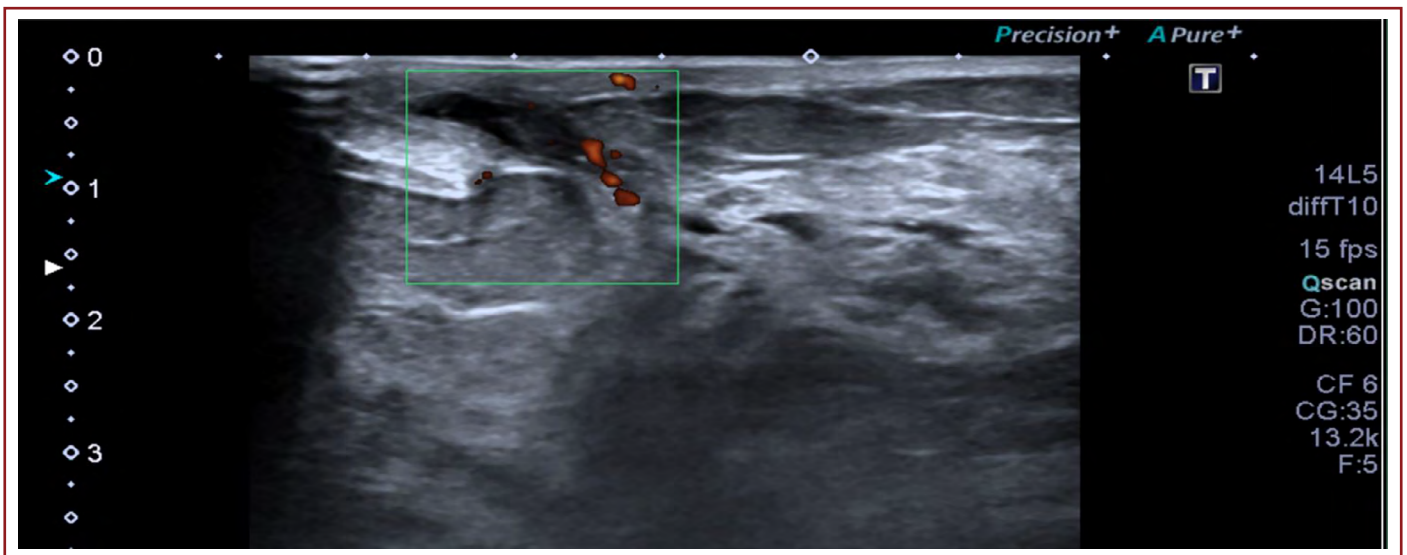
Solid lesion in an intraductal location with significant vascularization on color Doppler examination.
